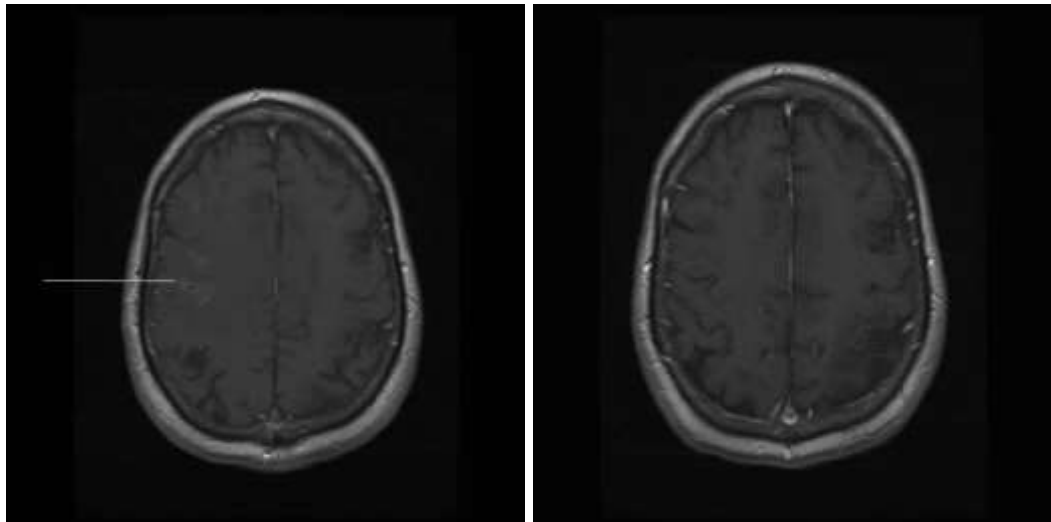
Primary CNS vasculitis. T₁-weighted MRI of the brain demonstrates gyral enhancement after intravenous administration of gadolinium before treatment (A), that resolves after immunosuppressant therapy (B). Reproduced with permission from [10].
